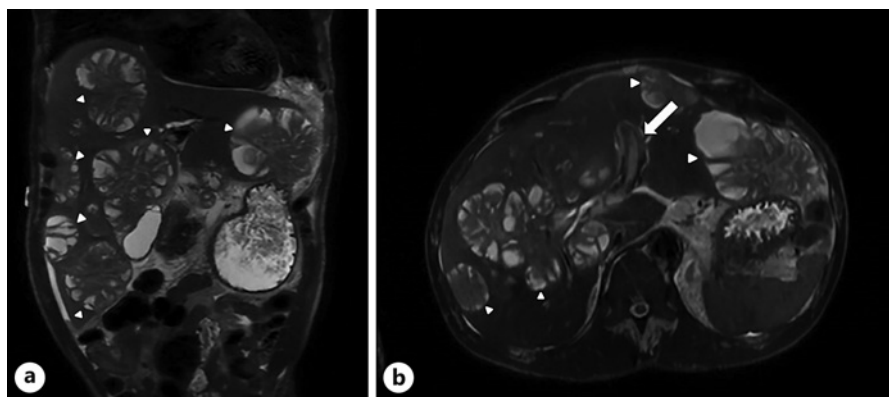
a MRI of the abdomen, showing numerous lesions throughout the grossly enlarged liver by white arrowheads. b White arrows point to an area of increased attenuation within the portal vein indicative of thrombus.
